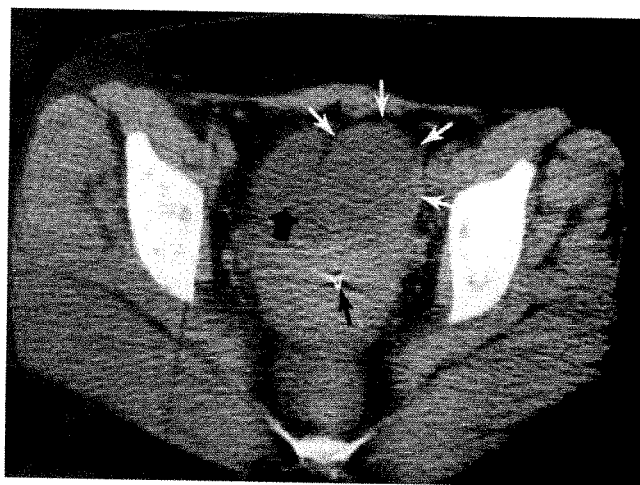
Asymptomatic 27-year-old woman with palpable left adnexal mass. CT scan showing sharply demarcated round 5 cm mass (white arrows) of low attenuation (5 EMU units) in left anterolateral aspect of pelvis. Urinary bladder (large black arrow) of identical attenuation to mass is displaced to right. Mass consistent with cyst. High density contraceptive device (small black arrow) present in center of uterus. Surgery disclosed benign left ovarian cyst.
